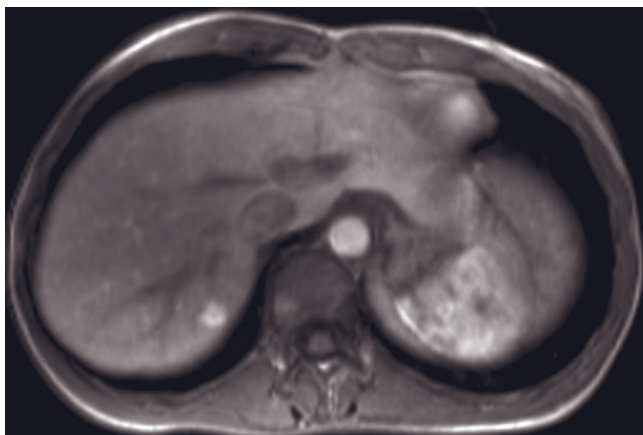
Atypical FNH imaged with Gd-EOB-DTPA. Echo-train STIR (a), SGE (b), out-of-phase SGE (c), and immediate (d) and 12-min hepatocyte phase fat-suppressed (e) post-Gd-EOB-DTPA SGE images. There is a lobular mass that is isointense on T2-weighted image (a) and T1-weighted image (b), but it is well seen on out-of-phase image (c) as a high-signal mass because of signal drop of surrounding fatty liver. Atypical for FNH is negligible enhancement immediately after gadolinium administration (d). Note the high signal of the mass on the hepatocyte phase fat-suppressed image (e) that reflects both signal loss in the fatty liver and Gd-EOB-DTPA uptake in the hepatocytes of the FNH.
